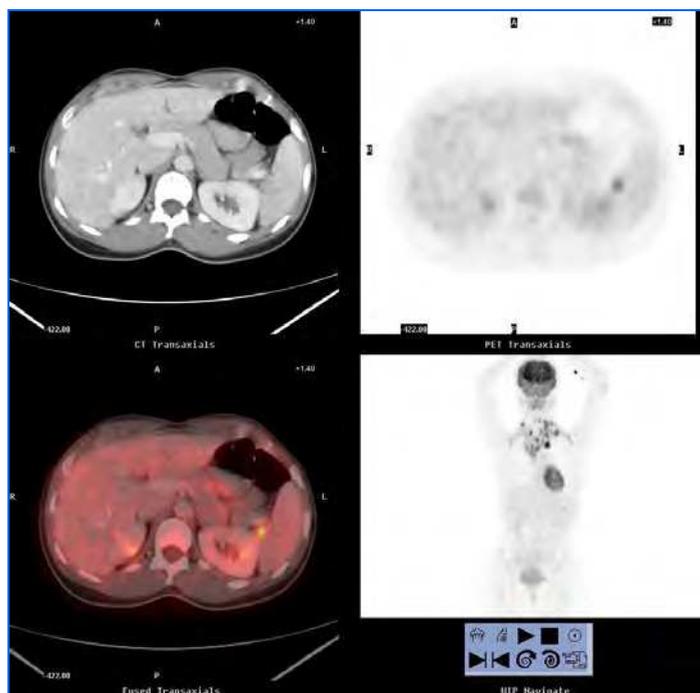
Axial section of CT with normal intravenous contrast. Axial section of PET. PET/CT detected a pathological FDG uptake in a small adenopathy in the splenic hilum. Therefore, the stage was increased from II to III.
